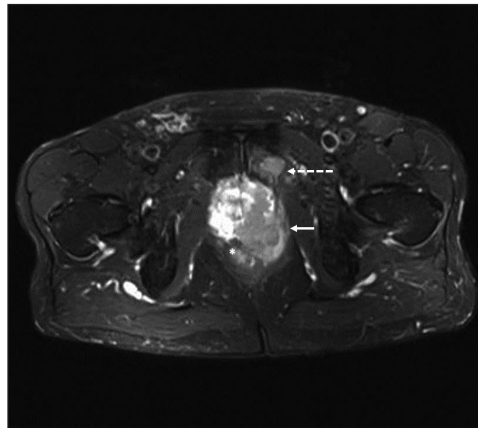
Fat suppressed axial T2 magnetic resonance imaging sequence: extensive lesion on the left lobe of the peripheral region of the prostate (white arrow) with signs of invasion of the prostate's transition zone (anteriorly) and periprostatic fat (posteriorly). This lesion is in contact with the left contour of the rectum's wall (asterisk), indicating its probable invasion. A lesion at the left iliopubic ramus with enveloping bone marrow edema (white dotted arrow) is also visible.
